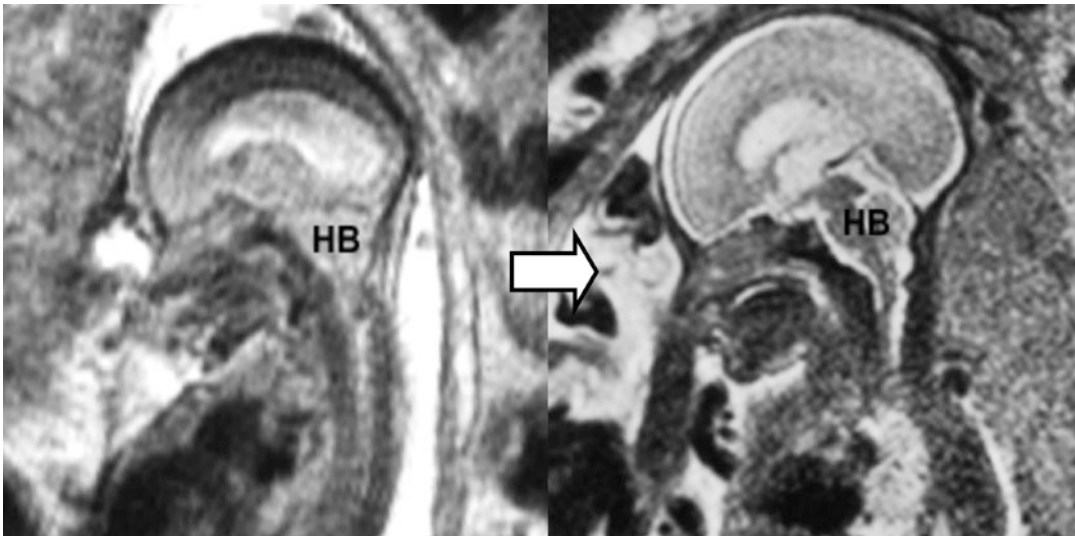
(a) MRI appearance of hindbrain herniation in Arnold-Chiari II malformation. (b) Reversal of hindbrain herniation 3 weeks after fetal repair of MMC. Fluid spaces
